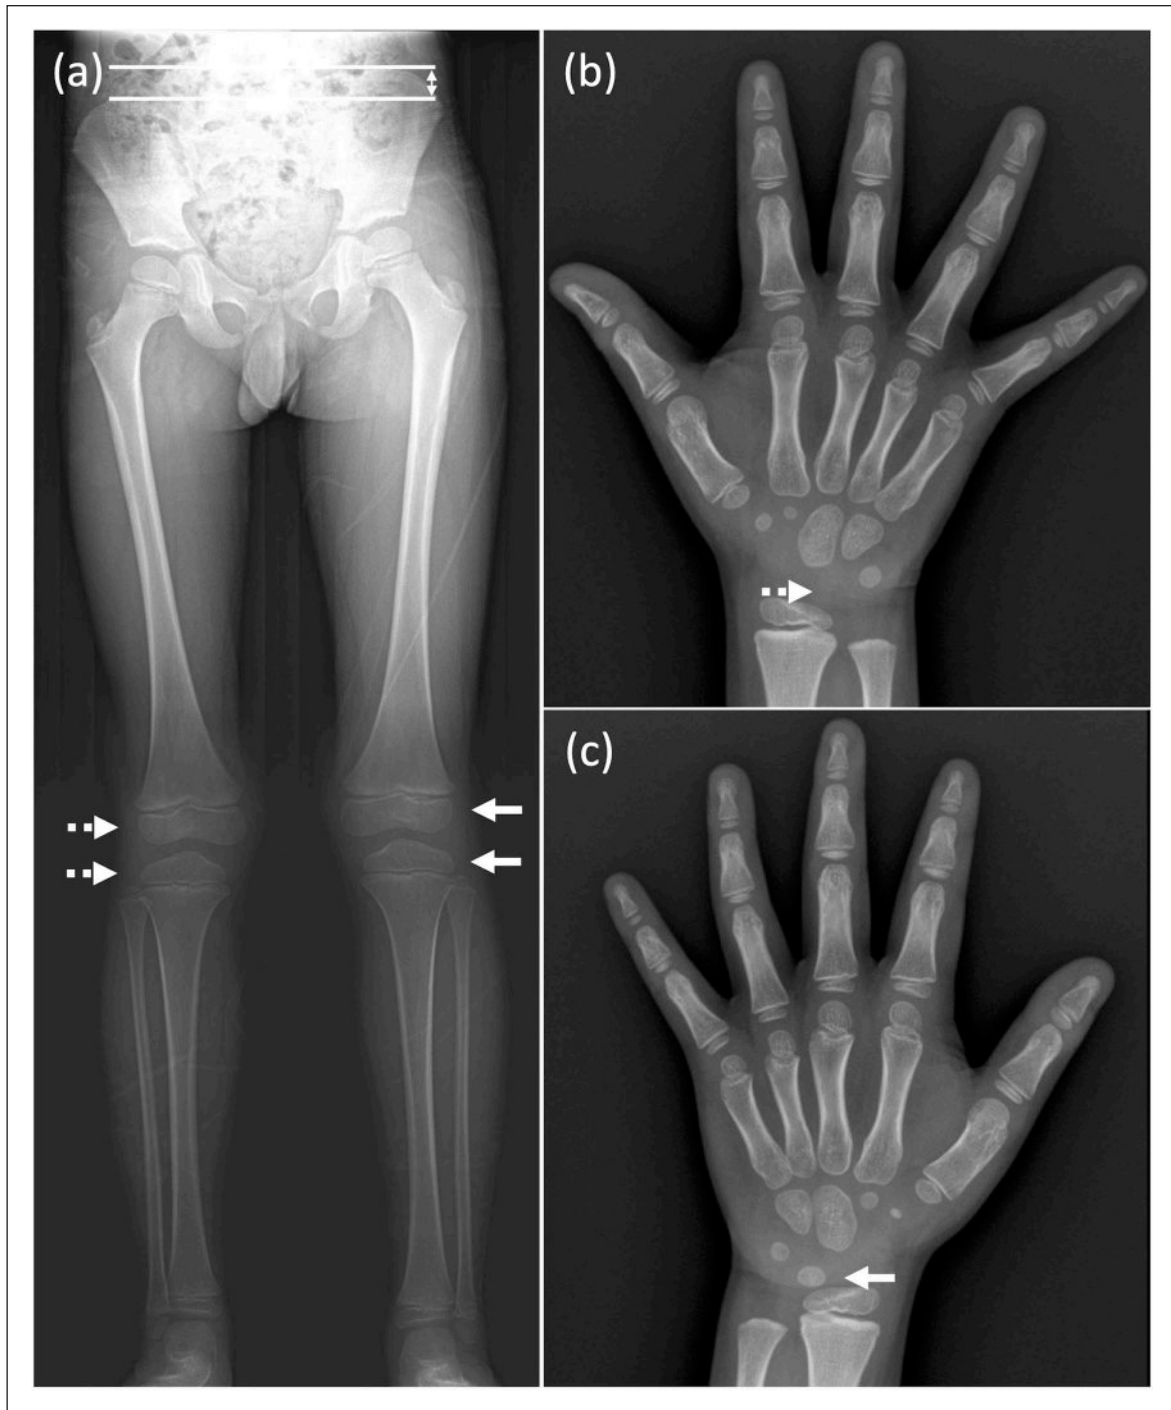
A 5.5-year-old boy with Beckwith-Wiedemann syndrome showing asymmetric skeletal maturation. (a) A whole-leg radiograph shows leg length discrepancy, with the left lower limb longer than the right. The epiphyses of the distal femur and proximal tibia are larger on the left side (solid arrows) than on the right (dashed arrows). (b and c) Bilateral hand radiographs demonstrate discordant bone age. The right hand (b) shows no ossification of the lunate (dashed arrow), consistent with chronological age (5.5 years). By contrast, the left hand (c) shows ossification of the lunate (solid arrow), indicating advanced bone age (6.1 years).
